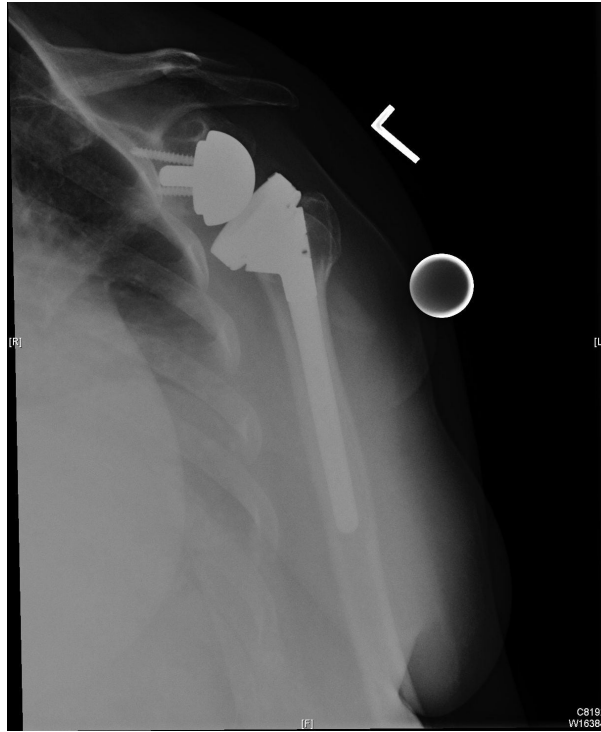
This radiograph shows an anteroposterior view of the left shoulder in a patient one year after a reverse total shoulder replacement for a four-part proximal humerus fracture.
